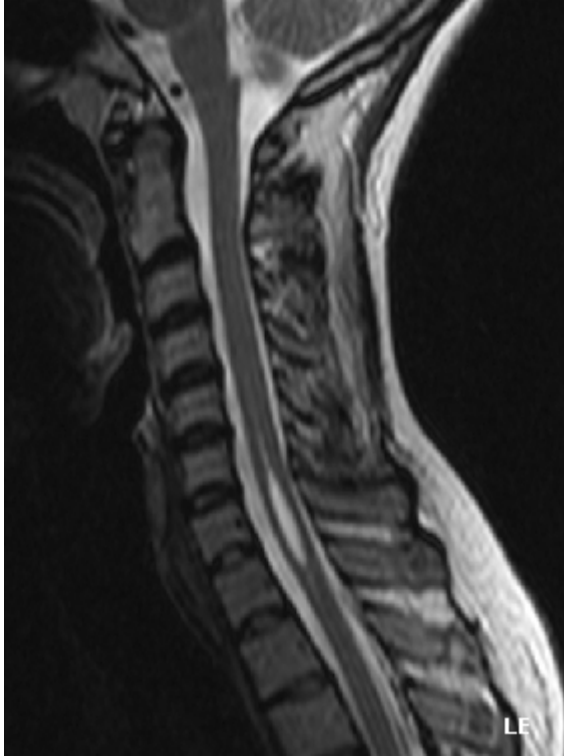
"T2-weighted MR image of a syrinx located at C6-C7 in the cervical spine" by Cyborg Ninja. License: Public Domain
